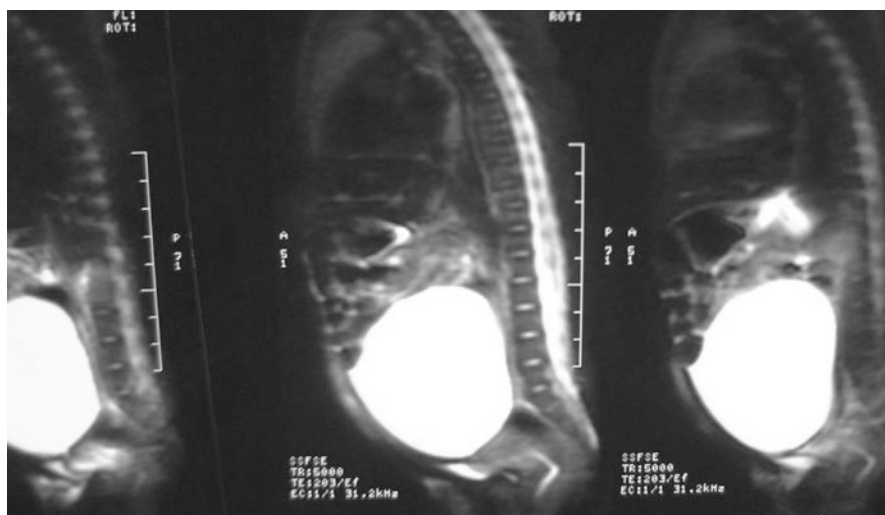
Abdominal MRI showing a large ovarian cyst in a newborn
